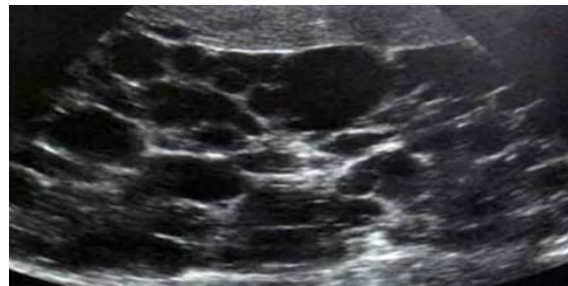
Abdominal ultrasound (oblique view) revealed markedly enlarged both kidneys, measured (22.5 X 12.5 cm) with multiple variable sized cysts.
